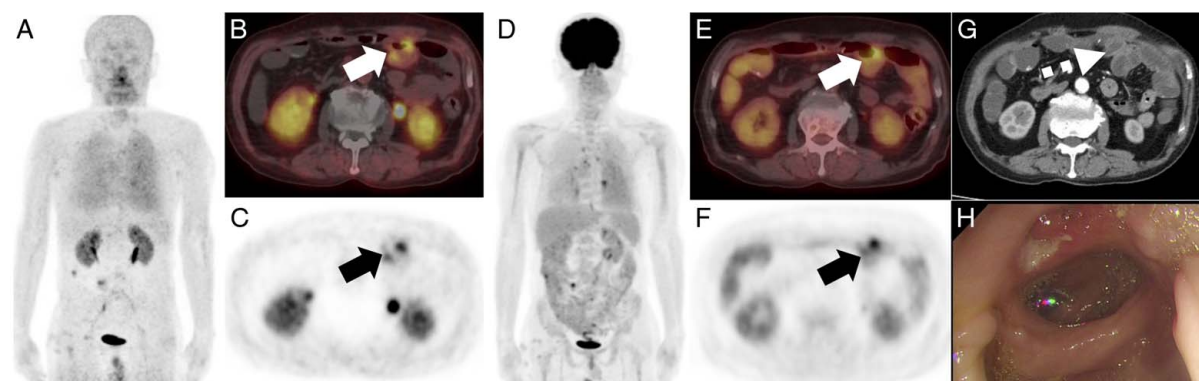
A 22-year-old man diagnosed with Crohn disease (Montreal classification A2L3B2+3P1, CDAI 128.7, simplified CDAI 5, SES-CD 4). The MIP of  $^{68}\text{Ga}$ -FAPI-04 PET (A) exhibited focal uptake in the right lower quadrant, localized to the terminal ileum according to the axial fusion image (B) and axial PET (C; SUVmax: 9.1, arrows). Furthermore, increased uptake was observed in the right sacroiliac joint. The MIP of  $^{18}\text{F}$ -FDG PET (D) showed physiological uptake in the ascending colon, while the uptake of  $^{18}\text{F}$ -FDG in the terminal ileum lesion was mild (E, axial fusion image; F, axial PET of  $^{18}\text{F}$ -FDG PET/CT, SUVmax: 3.8, arrows). Consistently, CTE (G) showed mural hyperenhancement and stricture in the terminal ileum (dotted arrow). The ileocolonoscopy confirmed stricture and ulcers in the terminal ileum (H).
